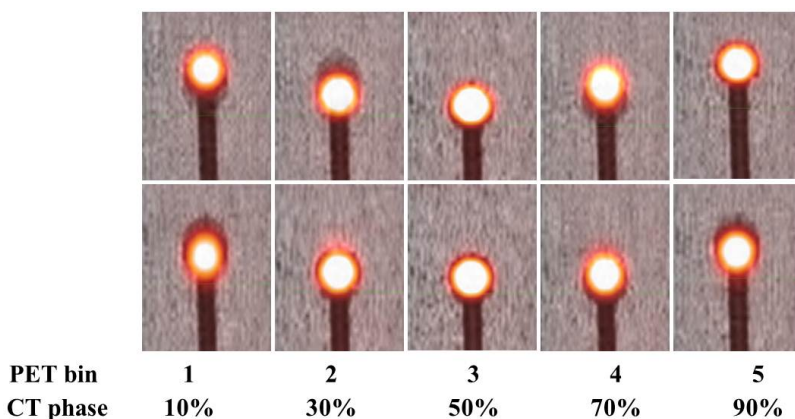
4DPET/CT images with phase-matched CT attenuation correction for two representative patient-specific respiratory motion cases
